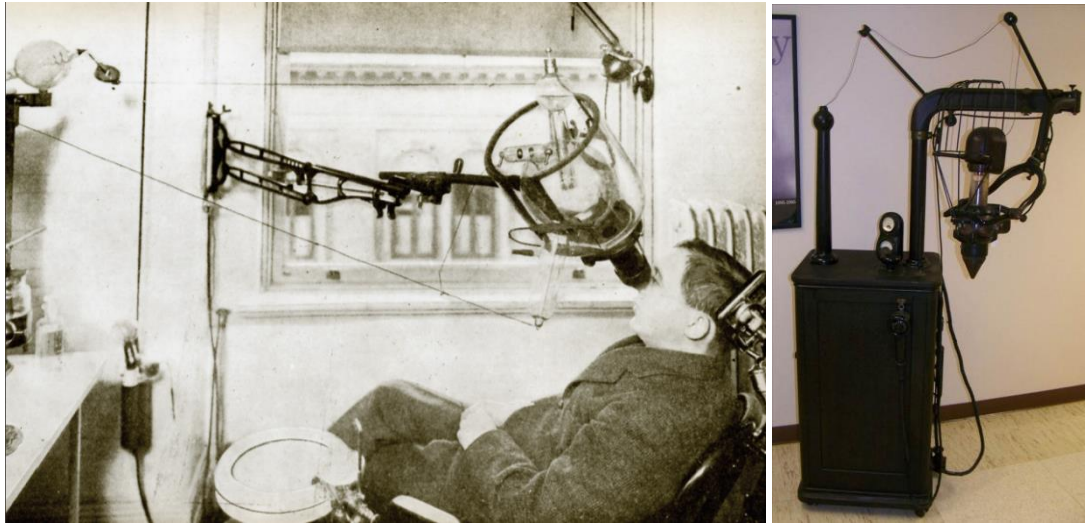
Left: early X-ray unit with exposed high-tension wire, which is believed to have several grave (even fatal) accidents [52]. Right: the Ritter dental X-ray unit (1928), despite using a Coolidge tube, still had an exposed wire. Open-tube units were manufactured until the 1930s. Courtesy of D. Bednarek (University at Buffalo) [56].
